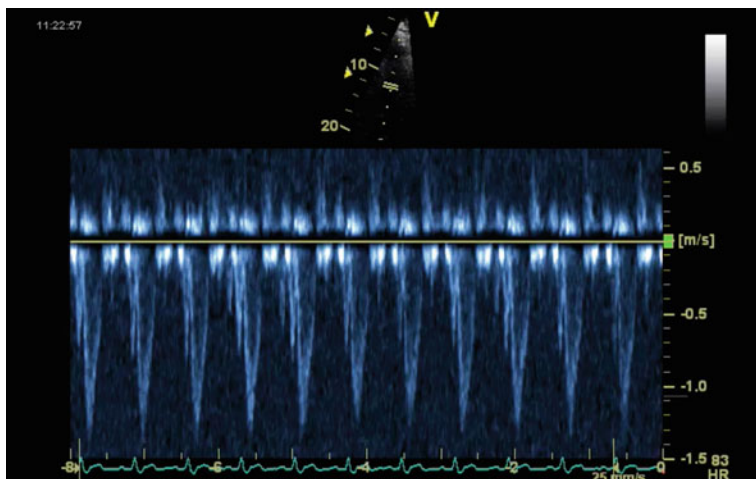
Pulse wave Doppler in the left ventricular outflow tract showing minimal change in velocity with respiration
